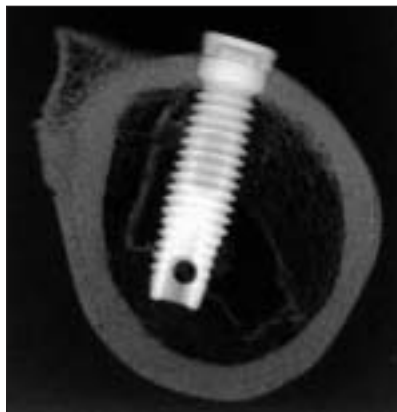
Radiographic image of a lateral incisor obtained with the SR imaging system.
